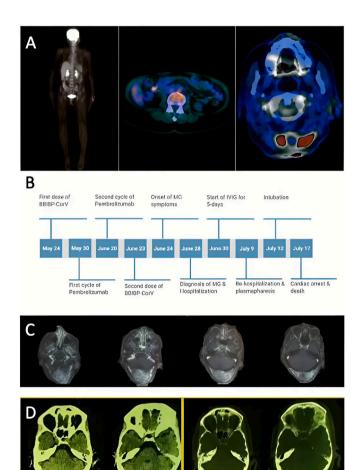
(A) Patient's initial PET/CT-scan showed FDG avid soft tissue mass adjacent to the surgical bed indicative of residual malignancy and an FDG avid subhepatic peritoneal soft tissue nodule in favor of metastasis; (B) Clinical timeline from diagnosis of tumor resection to MG diagnosis and hospitalization; (C) Patient's neck and brain MRI before starting immunotherapy showing a large soft tissue mass; (D) Significant tumor regression after two cycles of pembrolizumab.
